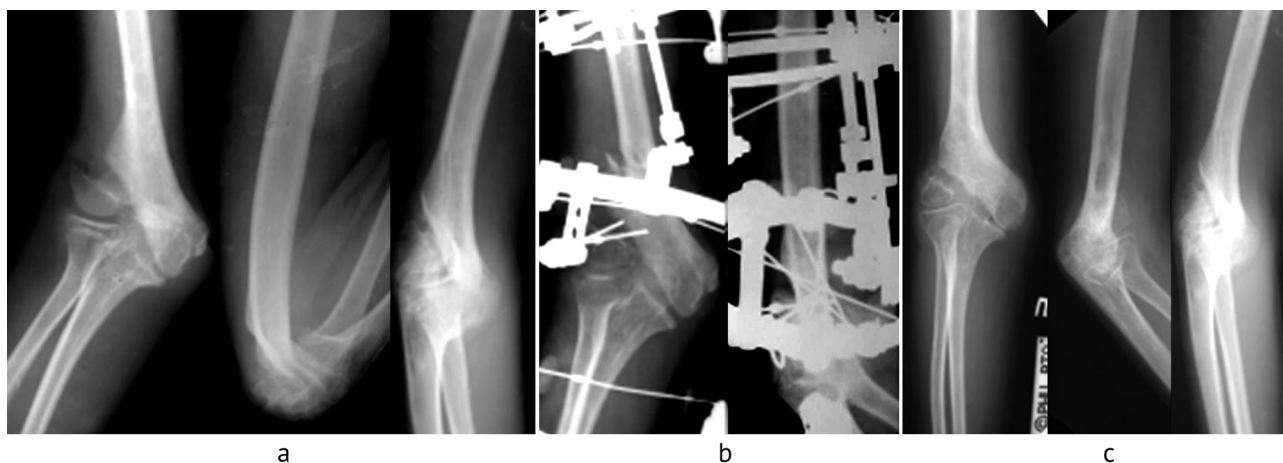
Photos from radiographs of an 11-year-old control patient with post-traumatic valgus deformity of the right elbow joint, defect of the lateral humerus condyle showing: (a) preoperative view; (b) supracondylar osteotomy of the humerus performed and valgus deformity of the elbow joint gradually corrected; the distal humerus fragment appears to be teeth-like, being located in the soft tissues (shown by the arrow); (c) a favorable outcome being with the bone fragment being demineralized at one year after removal of the Ilizarov apparatus
